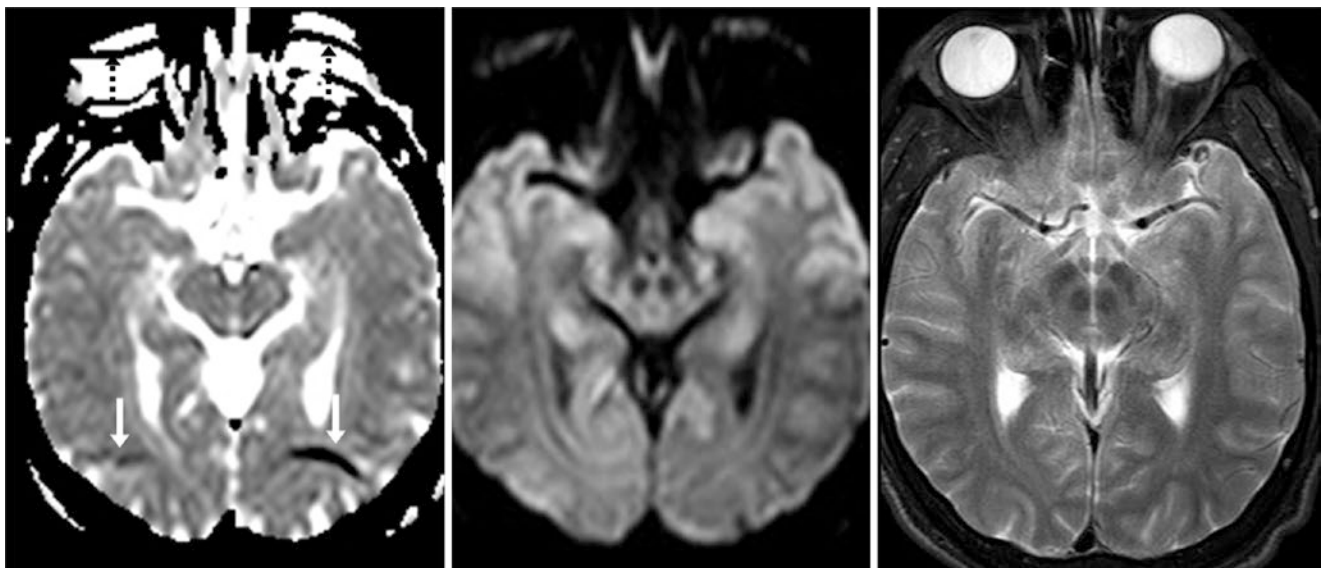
In a 30-year-old normal patient, 3 T MRI shows parieto-occipital unfolding artifacts (*white arrows*) on the ADC map (*left*), likely from the globes (*black dotted arrows*), as the phase direction is
